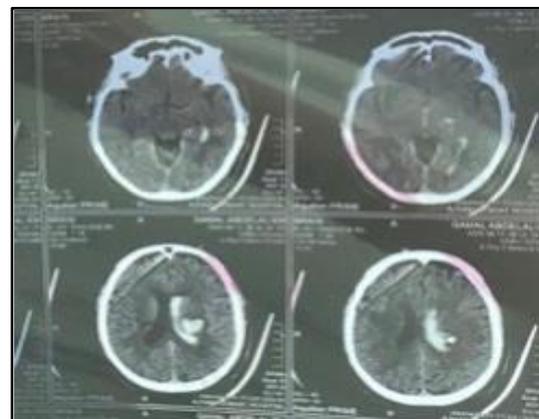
Brain CT scan revealed intracerebral haemorrhage.
